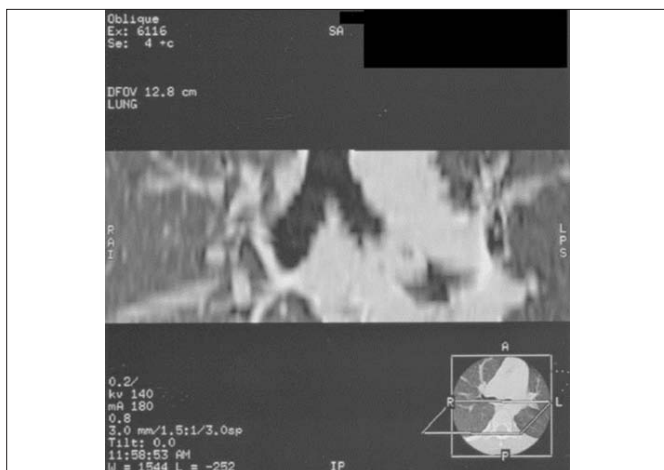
Computed tomography scan (coronal view) shows complete obstruction of the left bronchial lumen.
